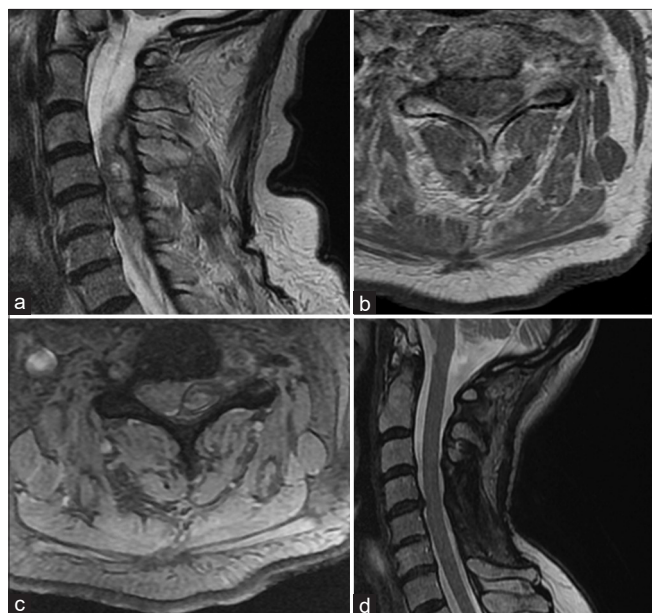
Preoperative MRI of the cervical spine. Sagittal (a) and axial. (b and c) sequences: Before (a) and after (b and c) contrast administration, a large, predominantly hyperintense extradural lesion at C4–C5 level, with heterogeneous prominent vascular flow voids and intralesional bleeding; it occupies the left side of the spinal canal, causing contralateral displacement of the spinal cord and extends through the left C4–C5 vertebral foramen in the parasagittal space. (d) Postoperative MRI, sagittal T2 sequence: Resolution of the spinal cord compression with slight residual hyperintense signal, MRI: Magnetic resonance imaging
